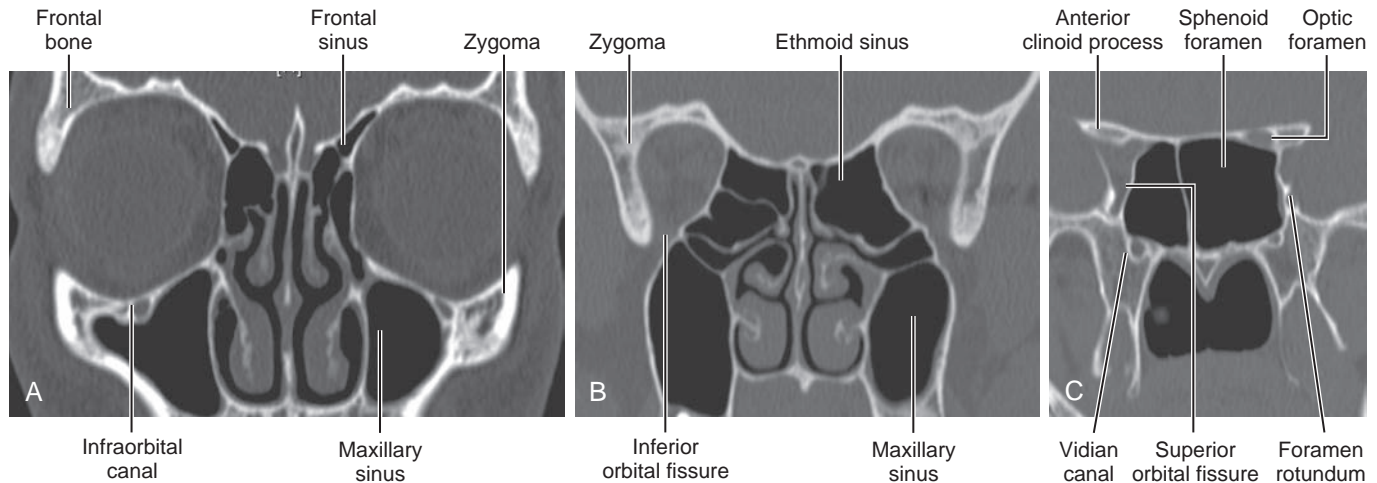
Coronal anatomy of the bony orbit. (A–C) Coronal noncontrast computed tomography images from anterior to posterior location.
